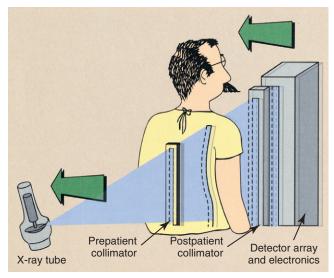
The components of a dedicated chest scanned projection radiography. (Courtesy Gary Barnes, University of Alabama, Birmingham.)
